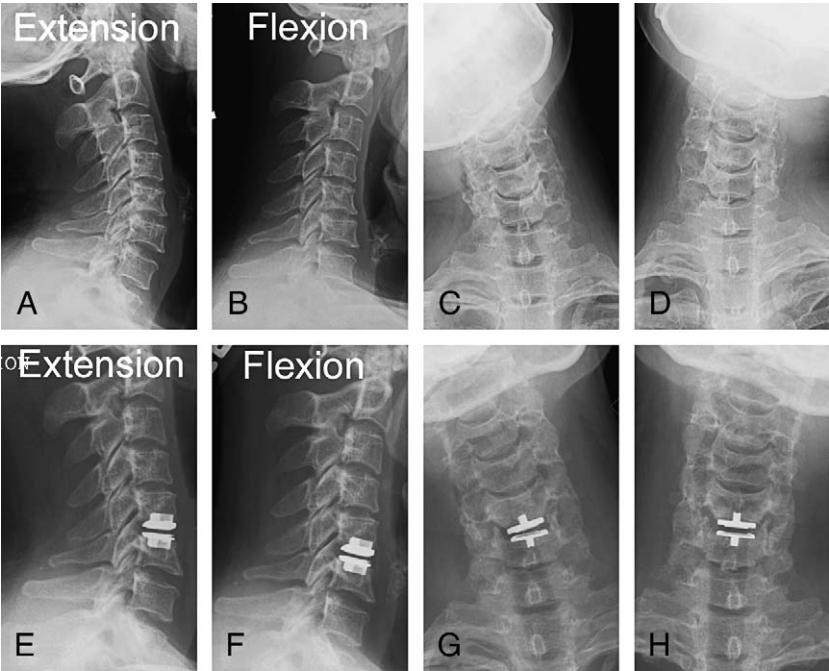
Pre-operative cervical spine radiographs in (A) extension, (B) flexion, (C) right lateral bending, and (D) left lateral bending. Cervical spine radiographs in the same patient following Prodisc-C arthroplasty at C5-6 in (E) extension, (F) flexion, (G) right lateral bending, and (H) left lateral bending.
